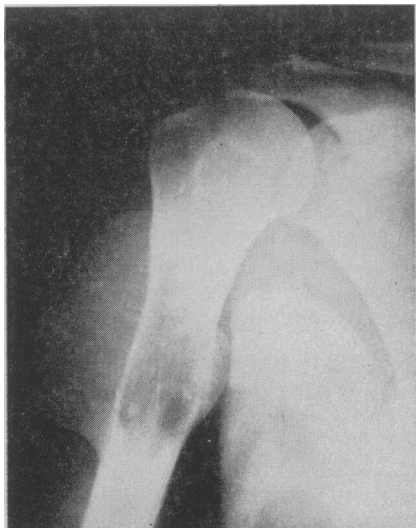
(Case IV).—Radiograph of the right humerus showing a thin-walled cyst arising from the shaft of the bone.
